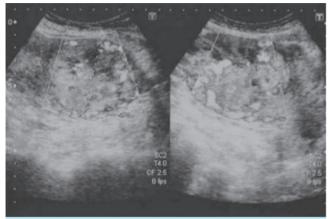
Pelvic ultrasound of patient, before commencement of treatment Large vascular mass of retained placental tissue measuring 9.0x6.0x6.5cm (vol. 160gms) have deeply penetrated into the myometrium.
